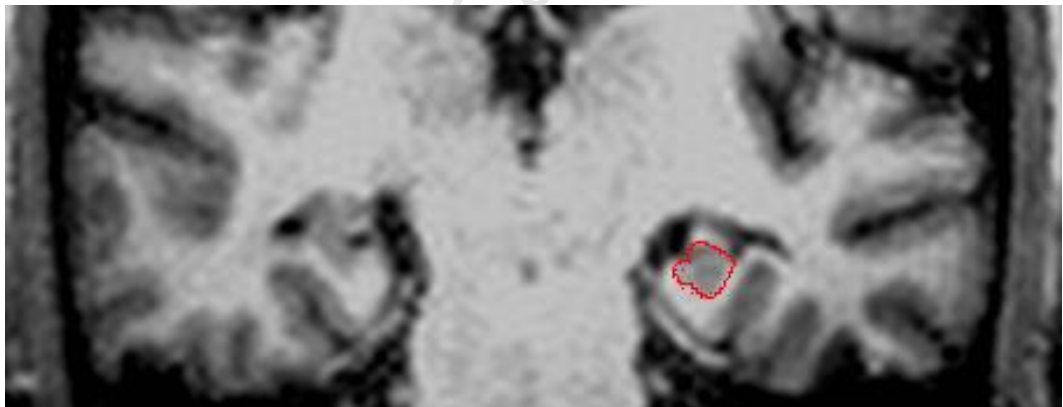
Coronal view of the anatomic borders of the left hippocampus, outlined in red, on MRI. Selected images from (A) a 69-year-old male control participant, and (B) a 69-year-old male AD patient.
